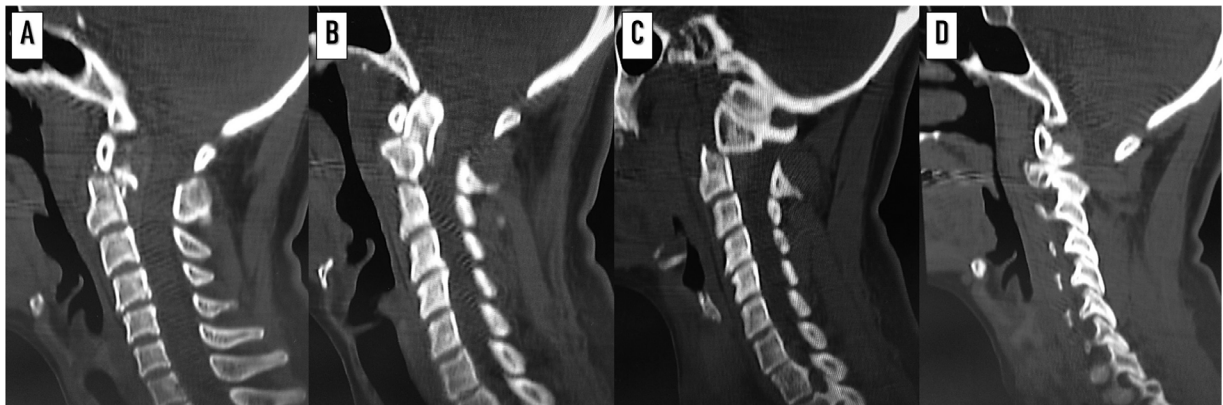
CT sagittal images showing atlanto-axial dislocation associated with a type IIB odontoid fracture (A-D).
